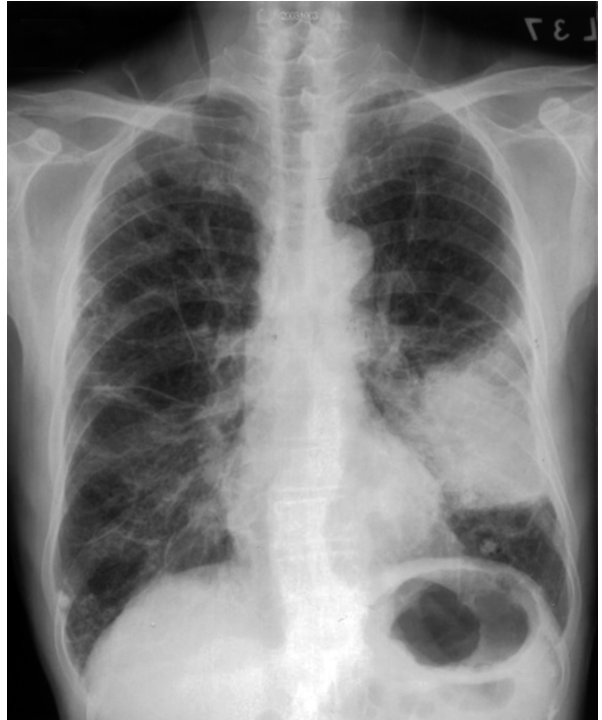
Chest radiography showing a mass (10 x 6 cm) in the left lower lobe and diffuse reticular infiltrations in both lungs
